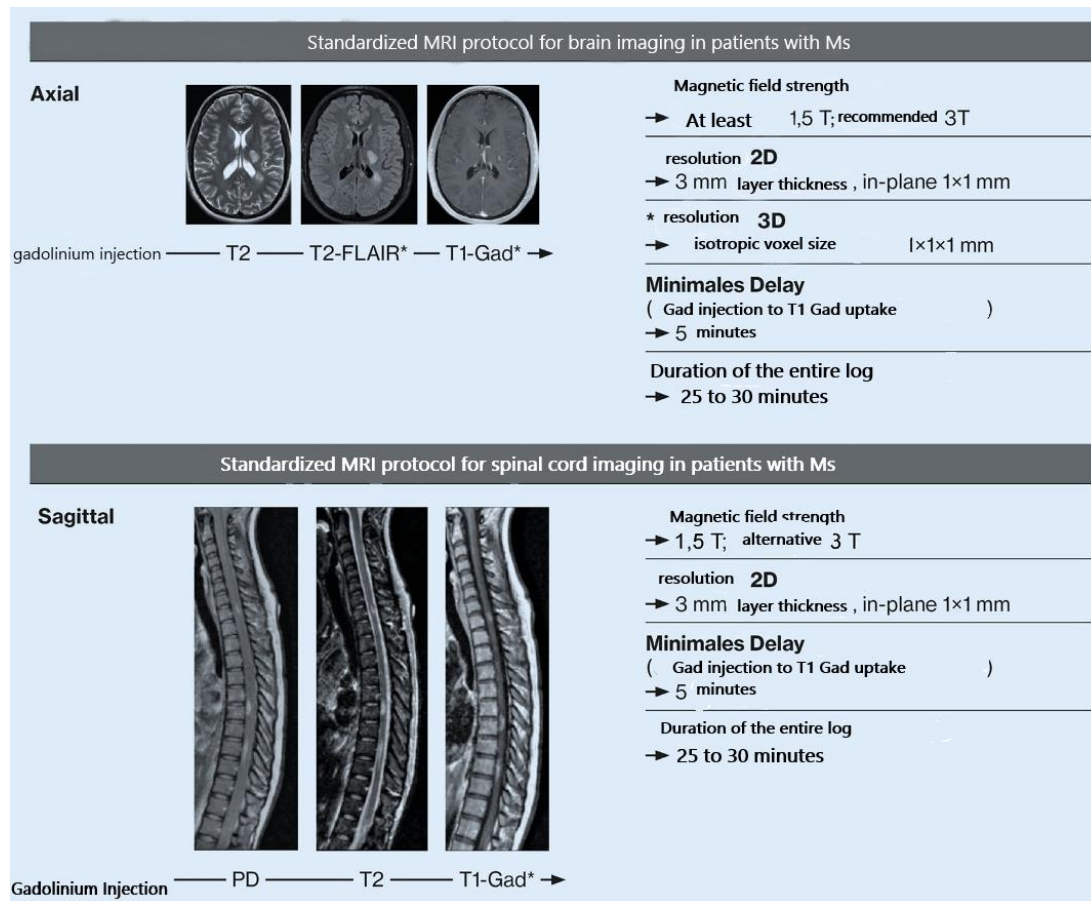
Internationally established MRI protocols in MS patients. (©M.P.Wattjes, Hannover).
